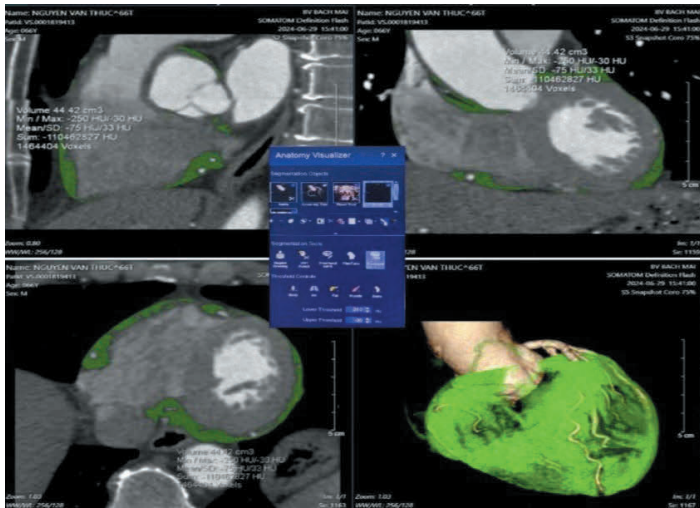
Analysis of epicardial adipose tissue (EAT) on computed tomography images
